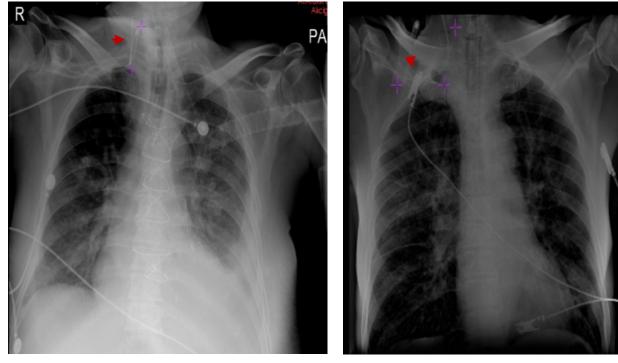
Chest radiograph showing a central line inserted in the right subclavian vein, catheter located at persistent right-internal jugular vein (arrow).
